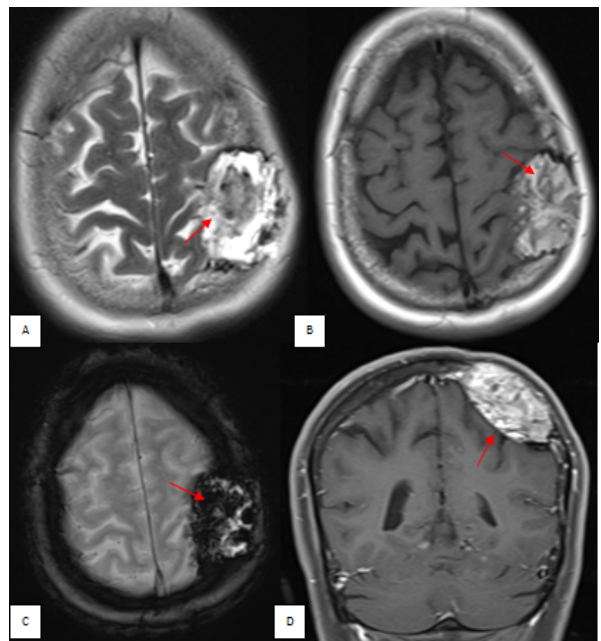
MRI of the brain showing a 55x35x25 mm sized left frontoparietal skull metastasis having heterogenously high signal intensity on axial T2w (A, arrow), spontaneous hemorrhagic hyperintensities shown on T1w (B, arrow) and signal void areas corresponding to the hemorrhagic components on GRE images (C, arrow). Prominent enhancement of the mass is demonstrated on coronal postcontrast T1w image (D, arrow). Note the epidural extension of the lesion with compression of the neural parenchyma without invasion
